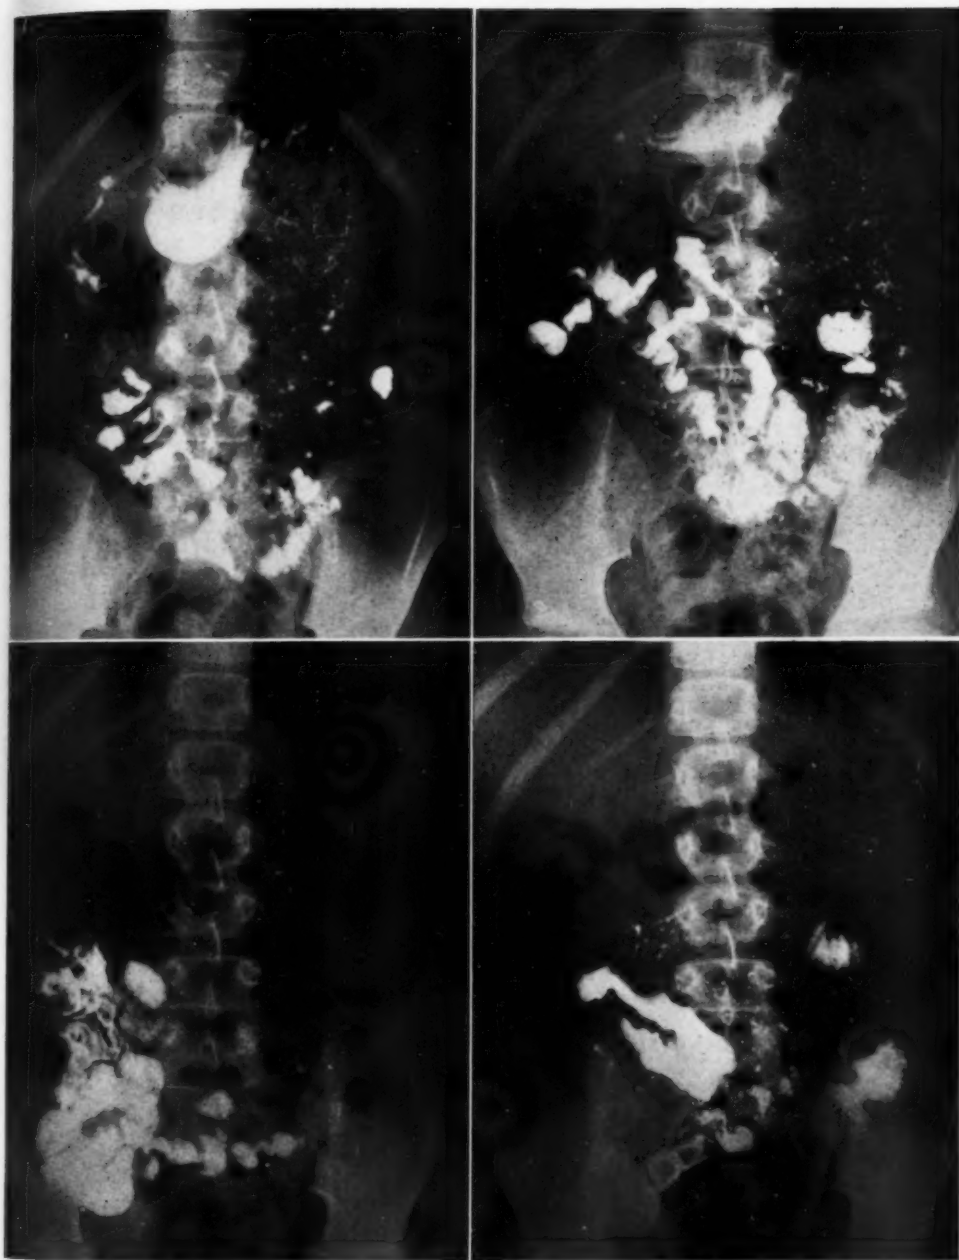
"Abnormal pattern" in a healthy girl, 9 years of age. In the upper left roentgenogram (one-half hour film) there are marked segmentation, irregular flocculation, and coarsening or obliteration of mucosal markings. Similar findings are observed in the other films of the series, and hypertonicity (string-like quality) of many loops is demonstrated.
